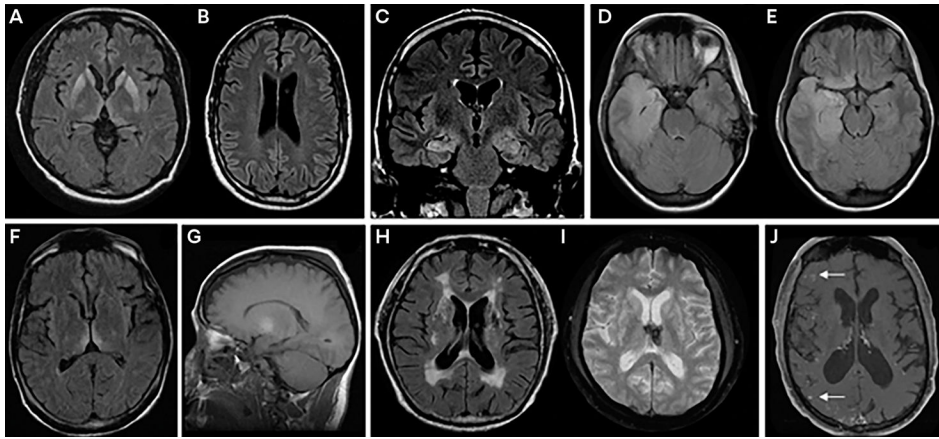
Neuroimaging findings associated with specific causes of rapidly progressive dementia. Creutzfeldt-Jakob disease: Axial fluid-attenuated inversion recovery (FLAIR) images show striatal thalamus (A) and cortical (B) hyperintensities. Autoimmune/inflammatory encephalitis: Coronal FLAIR image (C) shows bilateral limbic/hippocampal hyperintensities. Infectious encephalitis: Axial noncontrast FLAIR images (D, E) show right anteromedial temporal lobe hyperintensities in a patient with herpes simplex encephalitis. Metabolic/nutritional deficiency: Axial FLAIR image (F) shows dorsomedial thalamic hyperintensities in a patient with Wernicke-Korsakoff syndrome due to thiamine (vitamin B₁) deficiency; sagittal noncontrast T1-weighted image (G) shows diencephalon hyperintensity indicating metabolic encephalopathy in a patient with hepatic dysfunction. Vascular disease: Axial FLAIR image (H) shows strokes and diffuse ischemic white matter changes; axial gradient recalled echo (GRE) image (I) shows bilateral anterior and dorsomedial thalamic hemorrhage causing acute-onset amnesia; axial postcontrast T1-weighted image (J) shows enhancement of vessels in the right hemisphere (arrows), suggesting central nervous system vasculitis.
